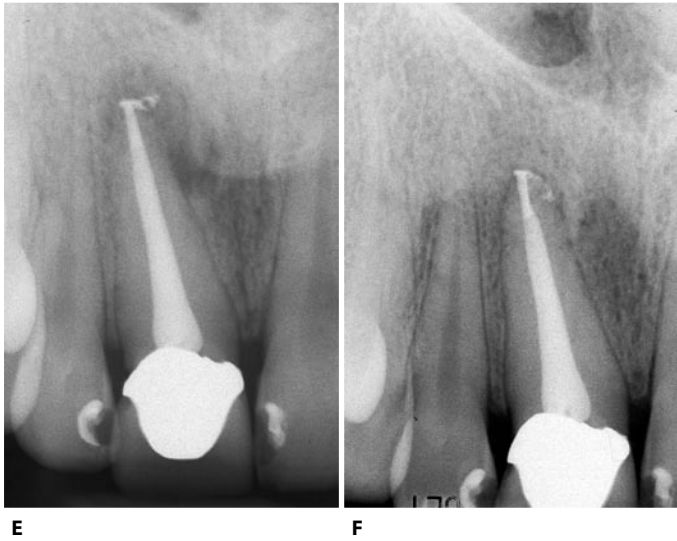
(continued) E. Postoperative radiograph following obturation with thermoplastic gutta-percha used according to the sectional technique. F. Two year recall.
